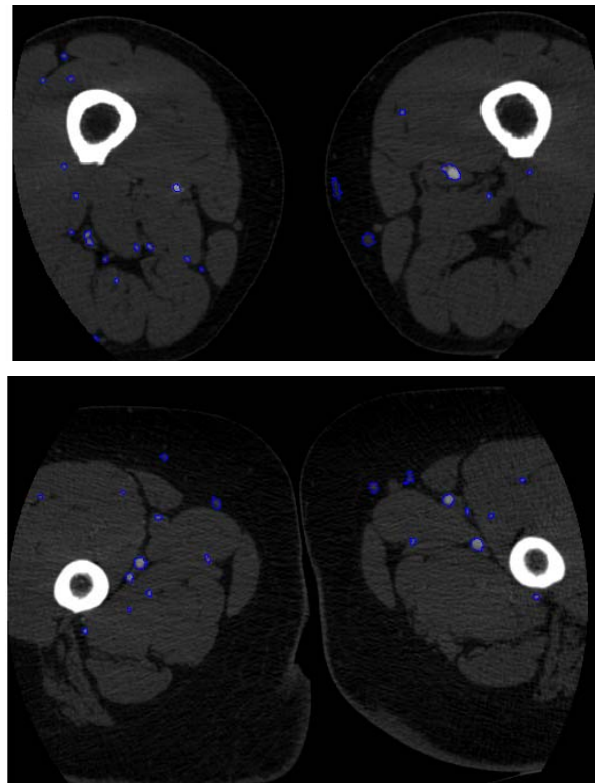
The results of artery segmentation in two cases of CT scans
